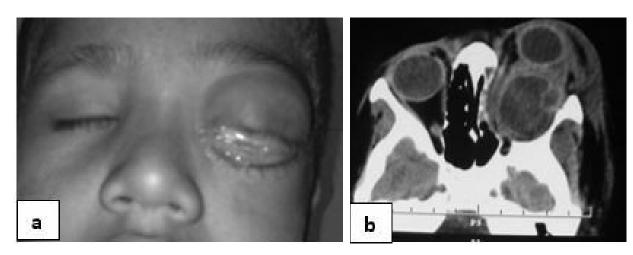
(a): Clinical picture of echinococcosis: lid oedema, chemosis, proptosis with ophthalmoplegia (left side); (b)- CT scan (axial section) of the orbits shows hydatid cyst in intraconal compartment of left eye with daughter cysts and bowing of medial orbital wall.
